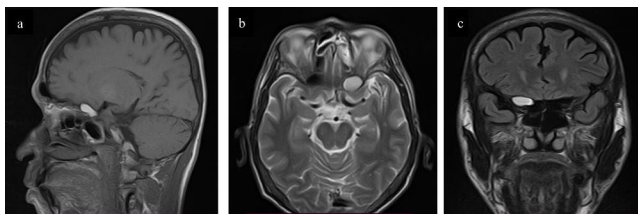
Pre-operative MRI s the anterior clinoid mass mucocoele. (a), (b) There is hyperintense T1 and FLAIR lesion located in the expected region of the right anterior clinoid process. The contralateral anterior clinoid process is pneumatized and hypointense in T1. (c) The lesion is hyperintense in T2WI, not suppressed on Flair - possibly due to proteinaceous fluid content of mucocoele
